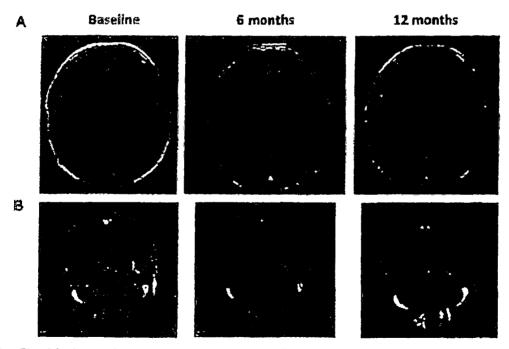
Exemplary T1 weighted magnetic resonance imaging (MRI) images with gadelinium from two Tumour Treatment Fields (TTF) patients with partial response to therapy. (A) A 48 years old male with prior grade II astrocytoma which transformed to glioblastoma (based on tissue blopsy. The subject progressed 7 months after receiving chemoradiotherapy, and subsequently responded to TTF therapy (partial response at 12 months) and remained stable for an additional 36+ months on TTF, (B) A 55 years old male with primary glioblastoma who recurred for the third time after receiving chemoradiotherapy, adjuvant temozolomide (2 cycles), bevacizumab with trinotecan (3 months) and erlottinib with sorafenib (one cycle). The subject had a partial response to TTF therapy after 4 months of treatment and remained stable for an additional 8 months while on TTF.
